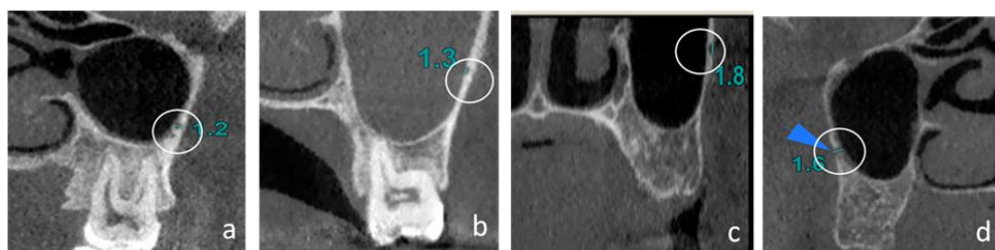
Coronal CBCT image showing diameter of PSAA canal; (a) intraosseous, (b) intrasinusal, (c) superficial, (d) transosseous
